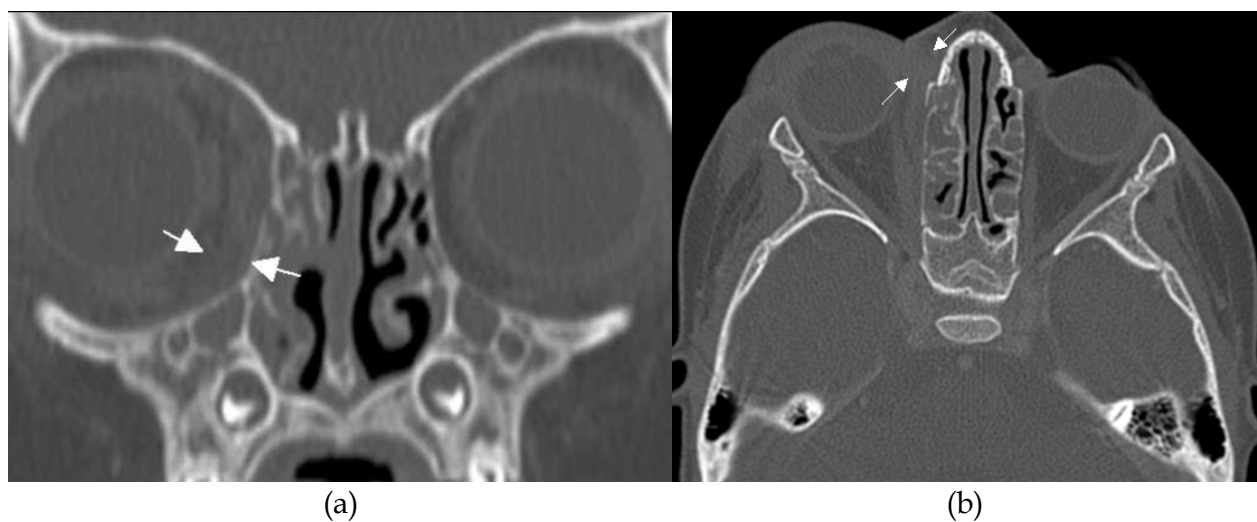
Coronal (a) and axial (b) CT show bilateral opacification of the ethmoid sinuses. On the right side there is exophthalmos due to spread of infection (arrows) from the right ethmoid sinus.
